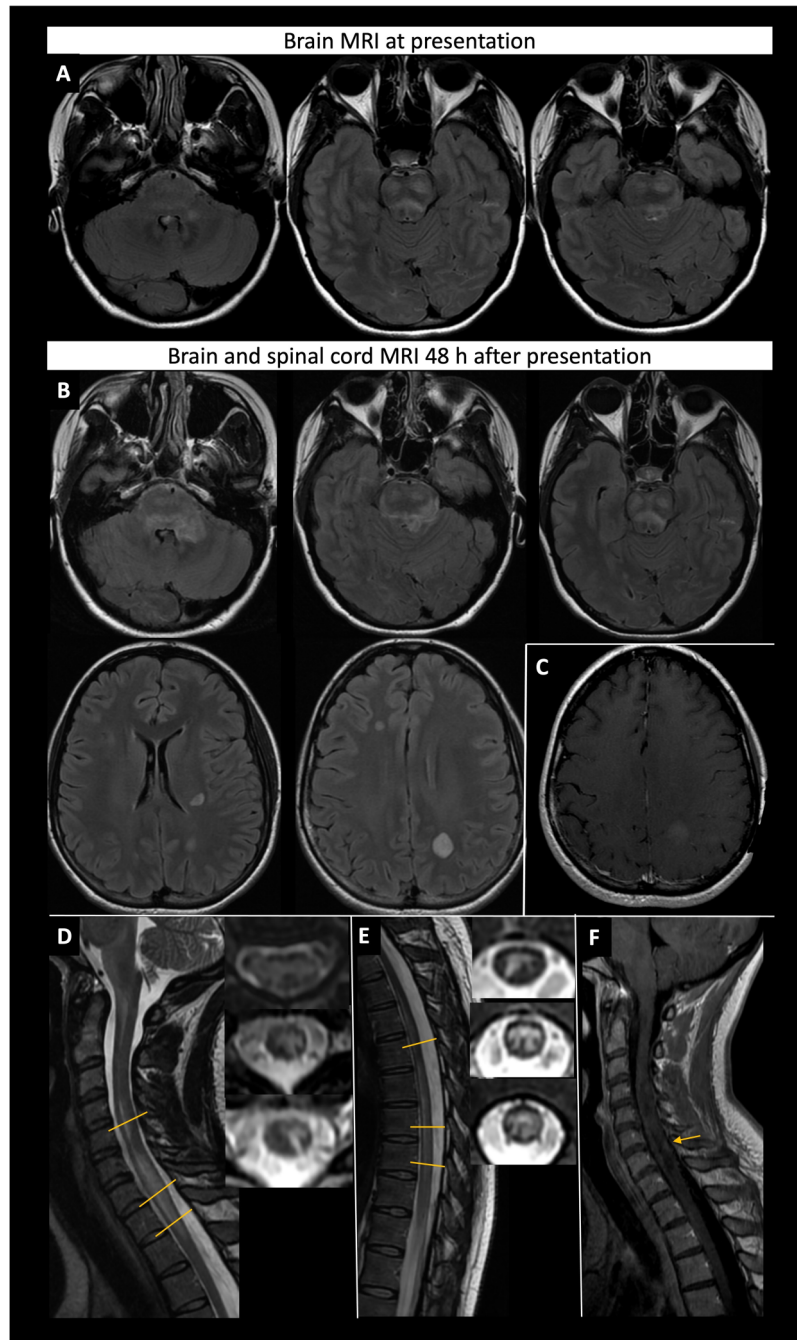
Brain and spinal cord MRIs at presentation. (A) Axial FLAIR sequences of first brain MRI at presentation, 3 days after symptom onset, showing subtle non-enhancing ill-demarcated abnormalities in the left middle cerebellar peduncle and the pons. No other abnormalities were identified on this MRI. (B) Axial FLAIR sequences of brain MRI 48 h after presentation, 5 days after symptom onset, showing worsening of abnormalities in the pons, bilateral cerebellar peduncles, and 3 new round white matter abnormalities in bilateral cerebral hemispheres suggestive of inflammatory demyelination with (C) enhancement of one of the lesions in the left parietal lobe on axial T1 sequences with gadolinium. Sagittal and axial T2 sequences of (D) cervical and (E) dorsal cord MRIs showing longitudinally extensive myelitis extending from C1 to T12, mainly confined to the grey matter, with (F) a focal faint nodular enhancement at the C7 level and prominent T1 hypointensity throughout the cord on axial T1 sequences with gadolinium.
